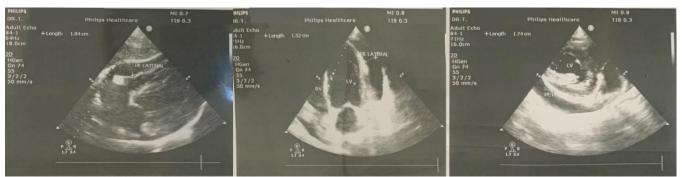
Echocardiography revealed moderate pericardial effusion
